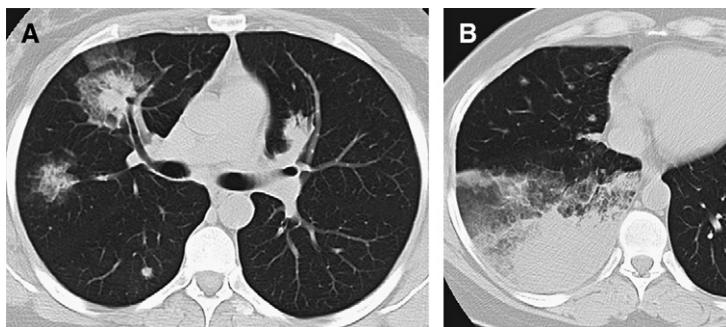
A 35-year-old nonsmoking woman with multifocal bronchioalveolar carcinoma. (A) CT image demonstrates bilateral masses with ground glass and solid components. (B) Dense consolidation in the right lower lobe and smaller nodules in the right middle lobe.
